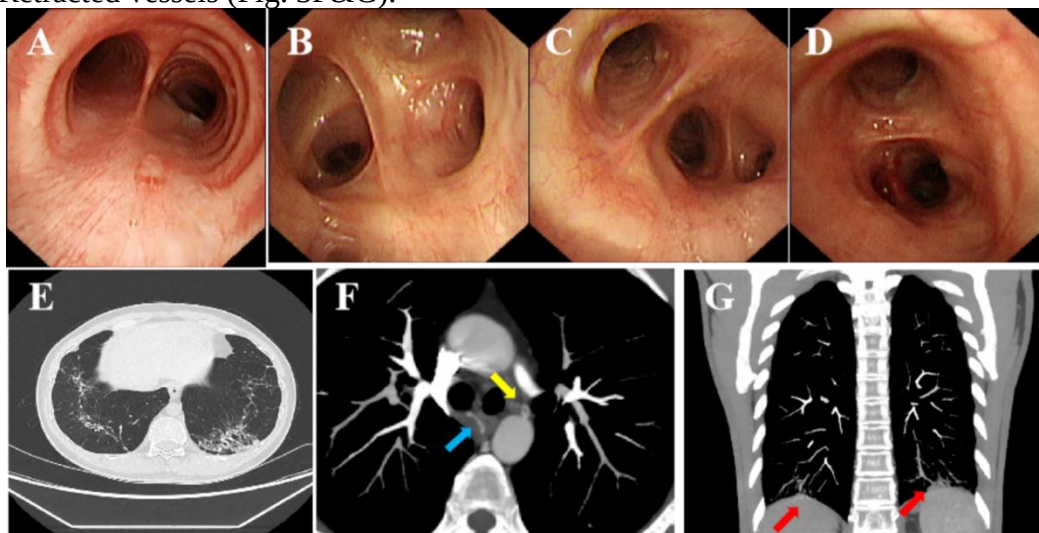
Bronchoscopy imaging of (A) the Carinal, (B) right superior lobar bronchus, (C) right middle lobar bronchus and (D) left superior lobar bronchus. (E) Non-contrast chest CT. Contrast-enhanced chest CT: Retracted left (yellow arrow) and right (blue arrow) bronchial artery (F), as well as pulmonary arteries and veins within the left lower lobe lesions and inferior phrenic artery (G).
